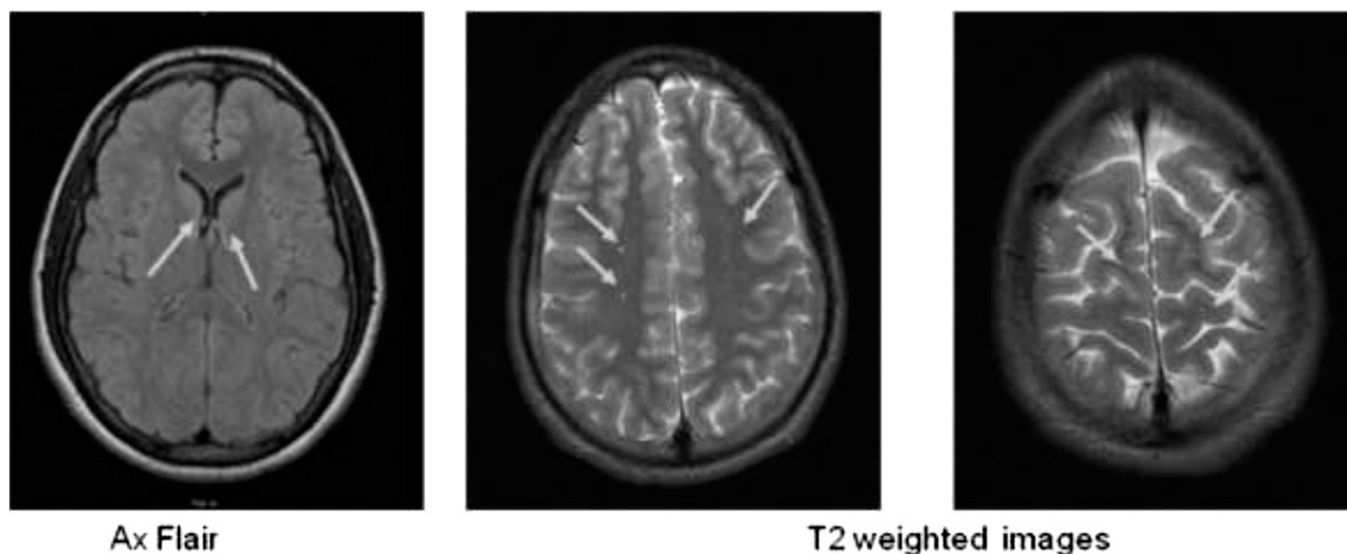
Basic 1.5T MRI of individual with concussions performed within 1 month after concussion. Arrows in Axial Flair and T2-weighted images (TE/TR = 103/4790 ms; FOV 424 × 23 mm; slice thickness = 5 mm, flip angle = 150°, matrix 0/512/224/0) depicted areas of micro bleeding and slightly increased number of enlarged high-convexity white matter VRS.
